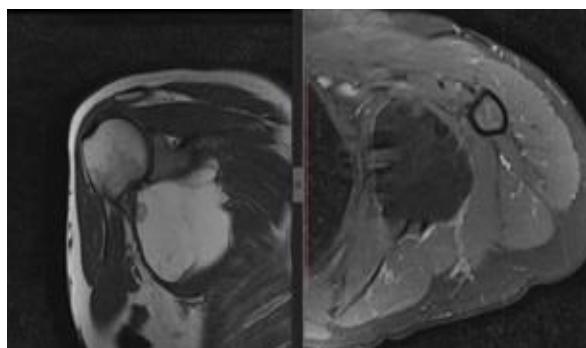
Heterogeneous appearance of the axillary area on MRI.
